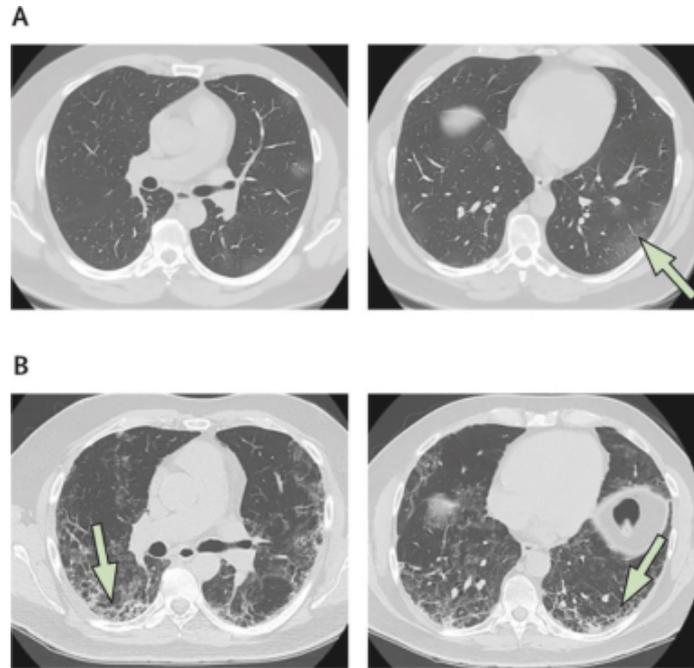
Lung CT of a COVID-19 patient. (A) Ground glass opacities (GGO) in the left lower lobe (arrow). (B) Three weeks later, in the same lung zones, the disease has rapidly progressed and fibrotic changes are now evident (arrows). Figure from Spagnolo et al., 2020
